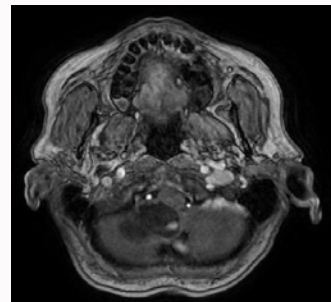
T1-weighted MR image with contrasting agent showing cystic tumour measuring 4.23 cm with intramural nodule of 0.88 cm.
